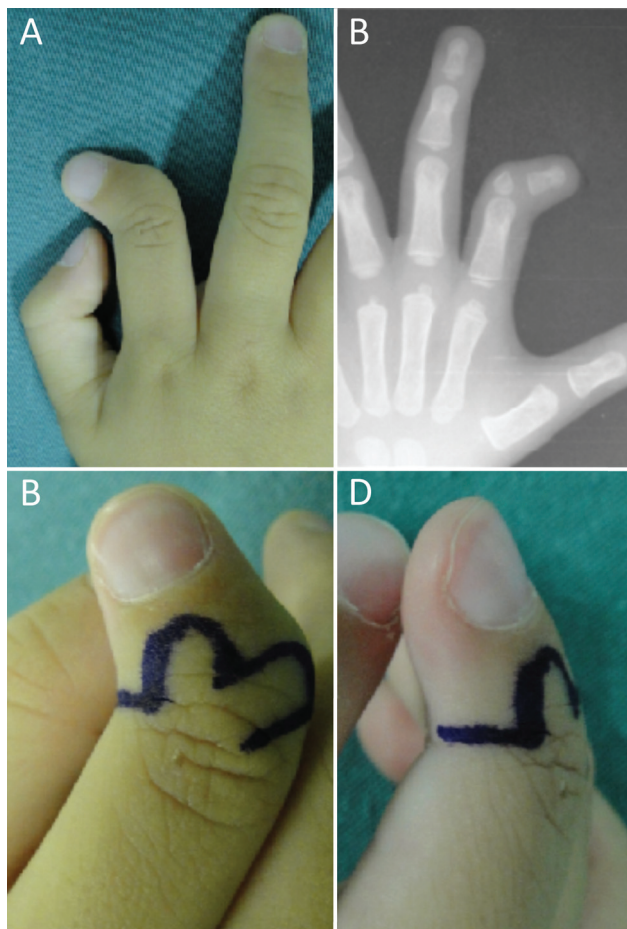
Patient with index finger clinodactyly. An isolated deformity not associated to any syndrome (A). Radiograph proves the abnormal development of middle phalanx. Delta phalanx (B). Surgical planning with bilobed skin flap (C and D).
